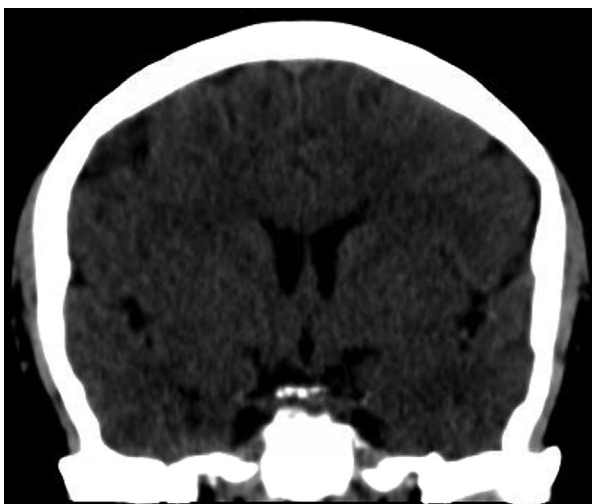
Noncontrast coronal CT of the brain showed no mass lesion compressing the optic chiasm. CT, computed tomography.
